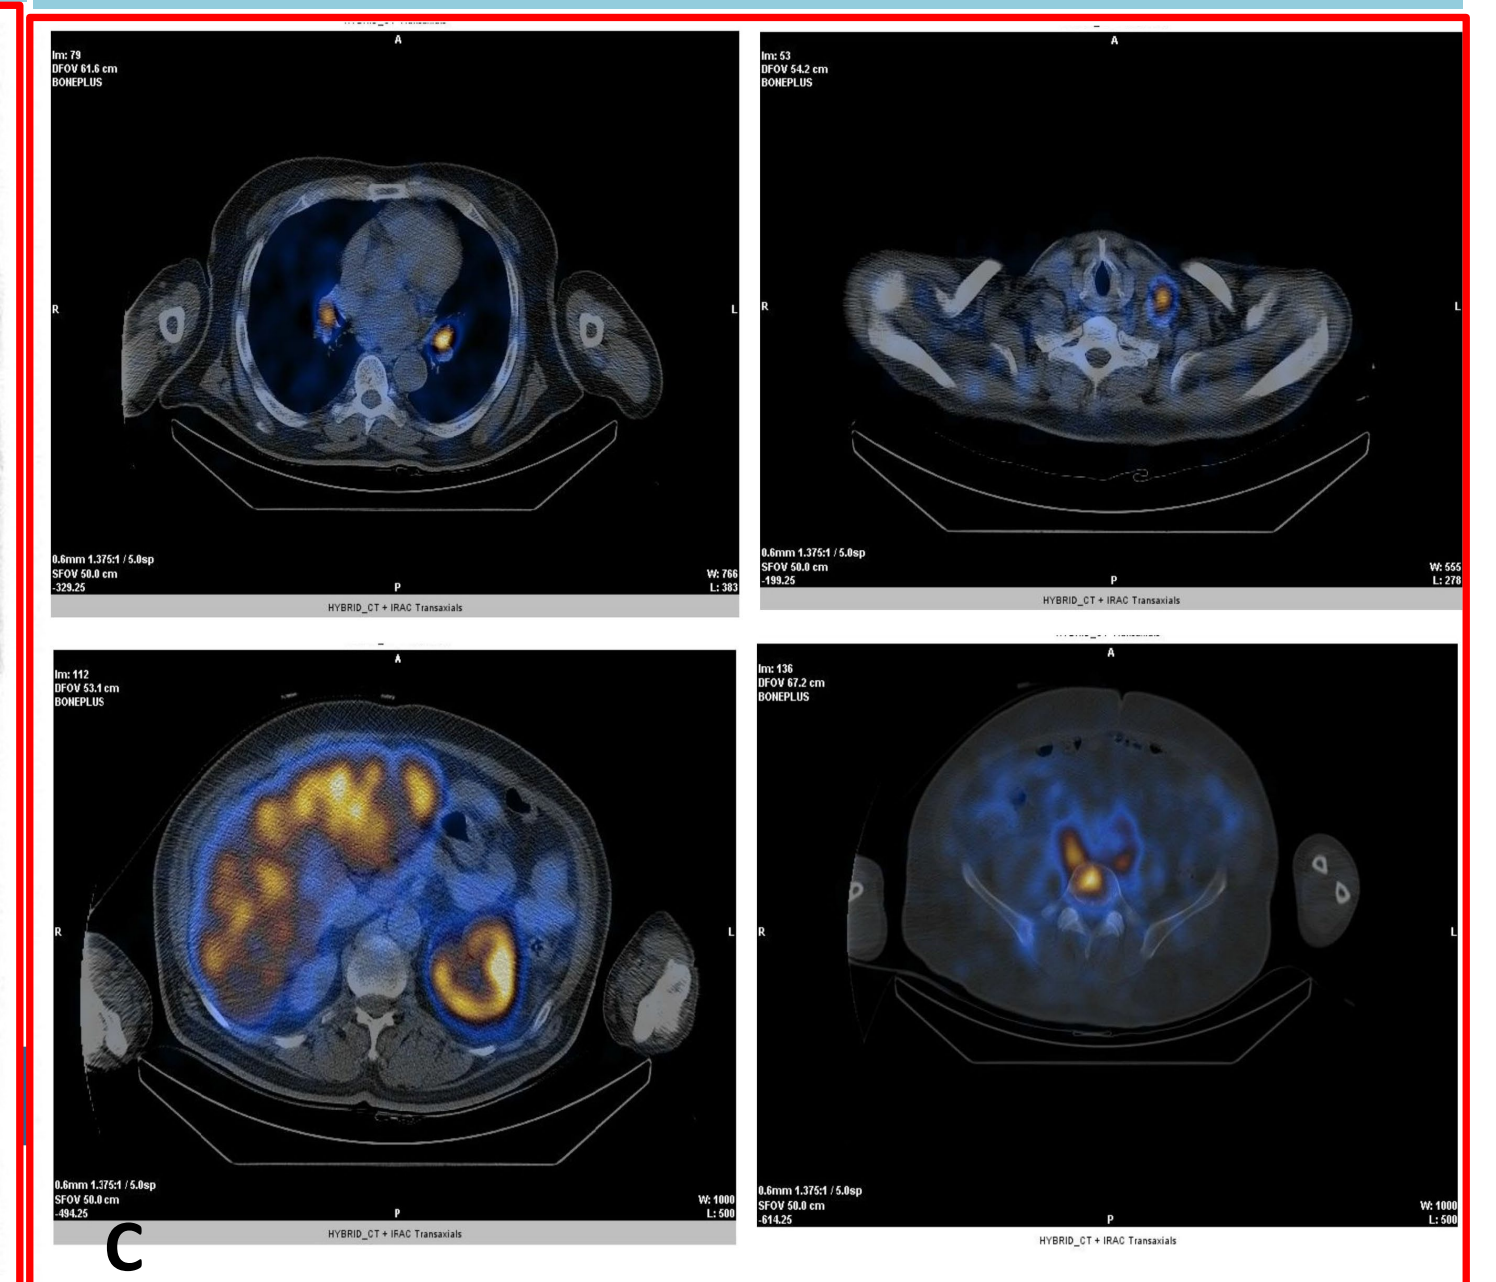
65yr/M with AdenoCA prostate, GS = 8 (4 + 4). (A) Whole-body scan showed suspicious lesion in L-5 vertebrae, right ilium and adjoining SI joint region.(B,C) ^{99m}Tc-PSMA-T4 SPECT-CT imaging showed bone (skull, right iliac blade, lumbar vertebrae and sacrum, right femur), and soft tissue mets(in liver, left cervical LN, B/L hilar, periaortic lymph nodes)
